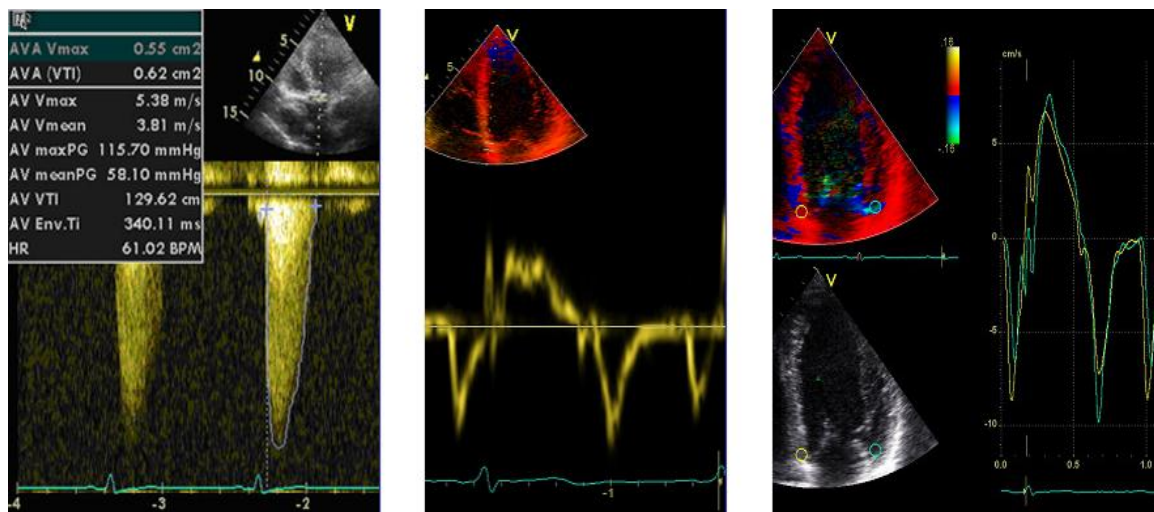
Spectral and trace analyses of flow and tissue Doppler velocity curves with velocity shown on the y-axis and time on the x-axis. Left figure: maximal velocity through a stenotic aortic valve assessed by continuous wave Doppler. Mid figure: Pulsed wave spectral TD curve with sample volume in the base of the inferioseptal wall showing systolic and diastolic mitral annular velocities. Right figure: Off-line colour TD trace analyses with systolic and diastolic mitral annular velocities of the base of the inferioseptal and anterolateral wall.
